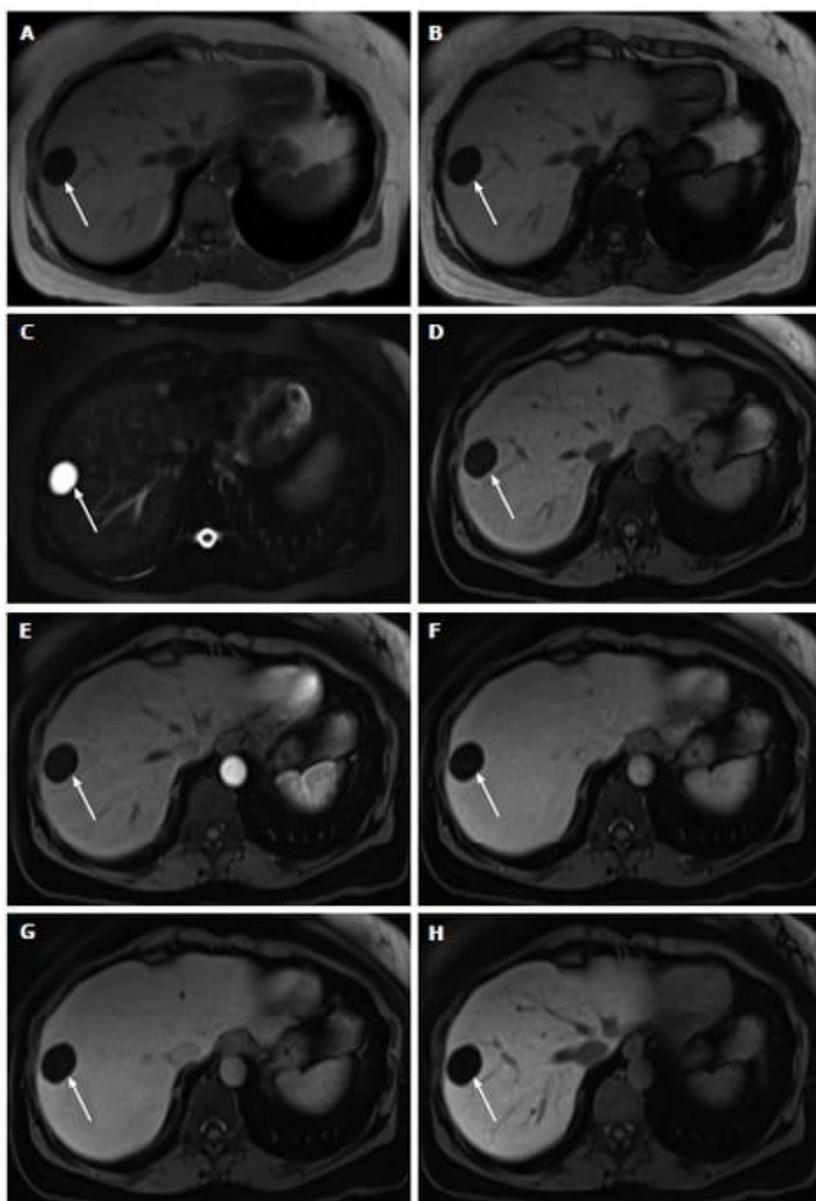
Cyst. In- (A) and opposed-phase (B) GRE T1-WI, fat-suppressed FSE T2-WI (C), pre (D) and post hepatocyte-specific contrast agent fat-suppressed 3D-GRE T1-WI at the arterial (E), portal venous (F), interstitial (G) and hepatobiliary (H) phases. There is a well-defined lesion on the right hepatic lobe (arrow, A-H) showing marked homogeneous low signal intensity on T1-WI (A, B and D), homogeneous very high signal intensity on T2-WI (C) and no enhancement after gadolinium administration (E-H), consistent with simple liver cyst. GRE: Gradient-echo; FSE: Fast spin echo; T1-WI: T1-weighted images.
